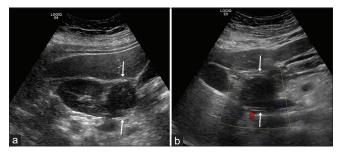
A 31-year-old male presented with the right-sided abdominal pain. (a) The gray-scale ultrasound images of the right upper abdomen demonstrated a 4.3 × 4.5 cm hypoechoic mass (arrows) inferior to the liver and medial to the right kidney. (b) Color Doppler ultrasound image shows no vascularity of the mass lesion.
